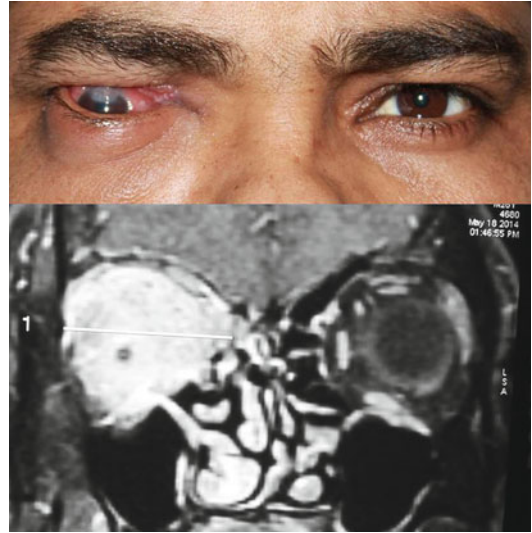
SGC of the right eyelid with orbital invasion presented with proptosis and restricted ocular motility. An MRI (*below*) shows the orbital component of the tumor as a hyperintense mass lesion
